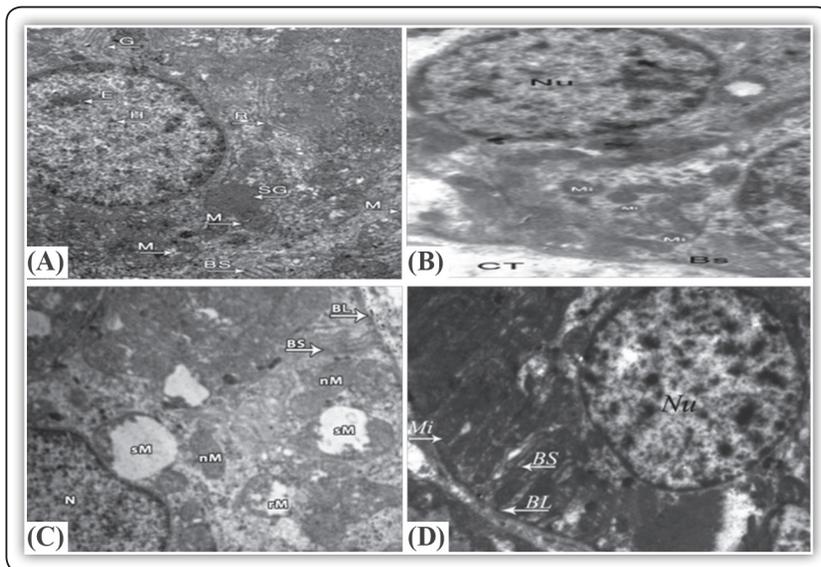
TEM presentations of striated ducts of SSGs. A: sham at 12 weeks; B: BoNTA-injected at 2 weeks; C: BoNTA-injected at 4 weeks; D: BoNTA-injected at 12 weeks; Nu:nucleus; Arrows: mitochondria lost internal cristae; SG: secretory granules; BS: basal striations; BL: basal lamina; CT: connective tissue; M:mitochondria; nM: normal mitochondria; sM: swollen mitochondria; rM: ruptured mitochondria.
